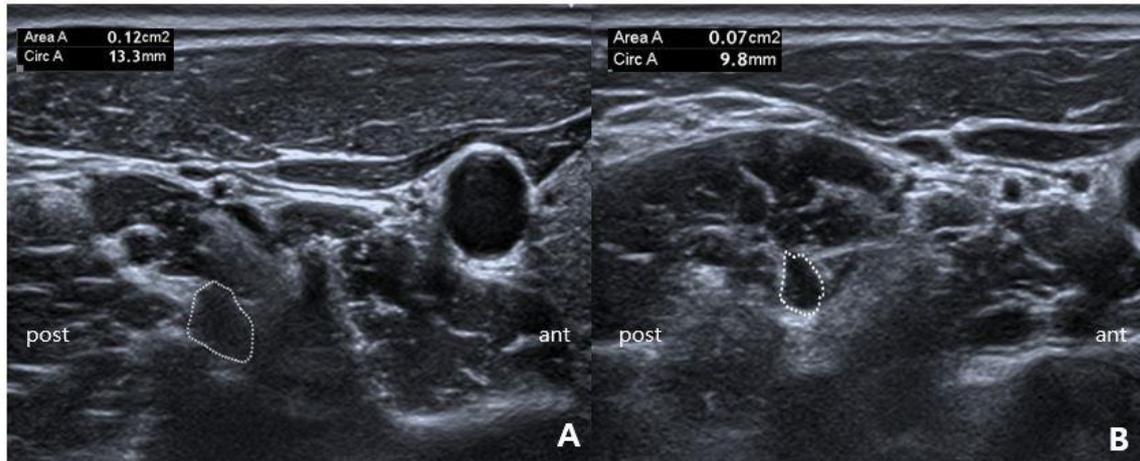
Transverse scan of C6 nerve root (dotted line) in a patient diagnosed as left C6 CR. The CSAs of the affected (A) and unaffected (B) sides were measured with trace tool at most proximal location, which can be detectable in ultrasonography. NR nerve root, CR cervical radiculopathy, CSA cross-sectional area, ant anterior, post posterior
